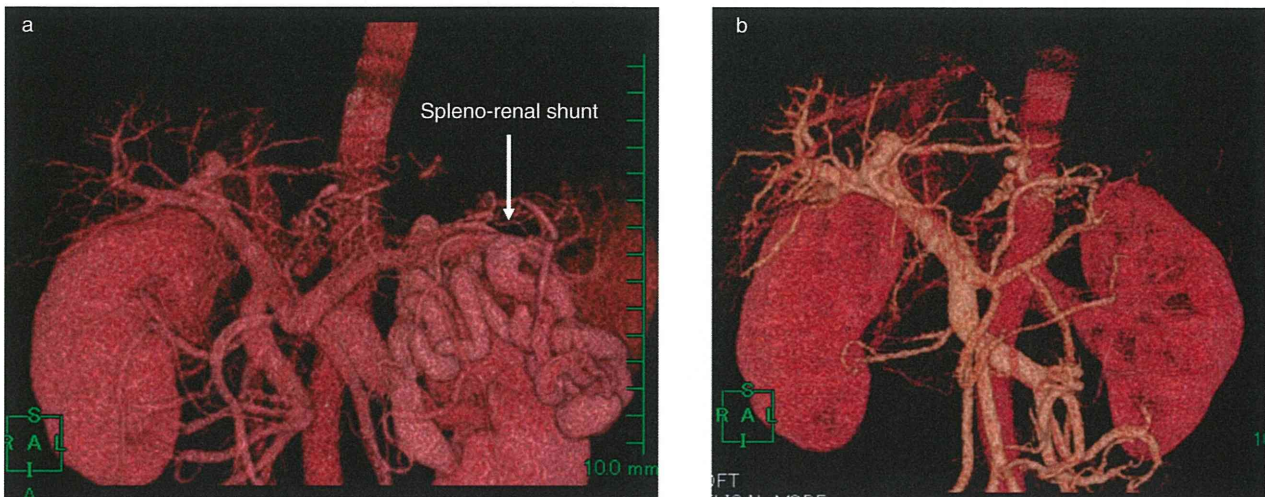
Three-dimensional computed tomography (CT) of the portal vein in case 1. (a) CT before surgery showing huge spleno-renal shunts. (b) CT after surgery showing disappearance of a spleno-renal shunt.
